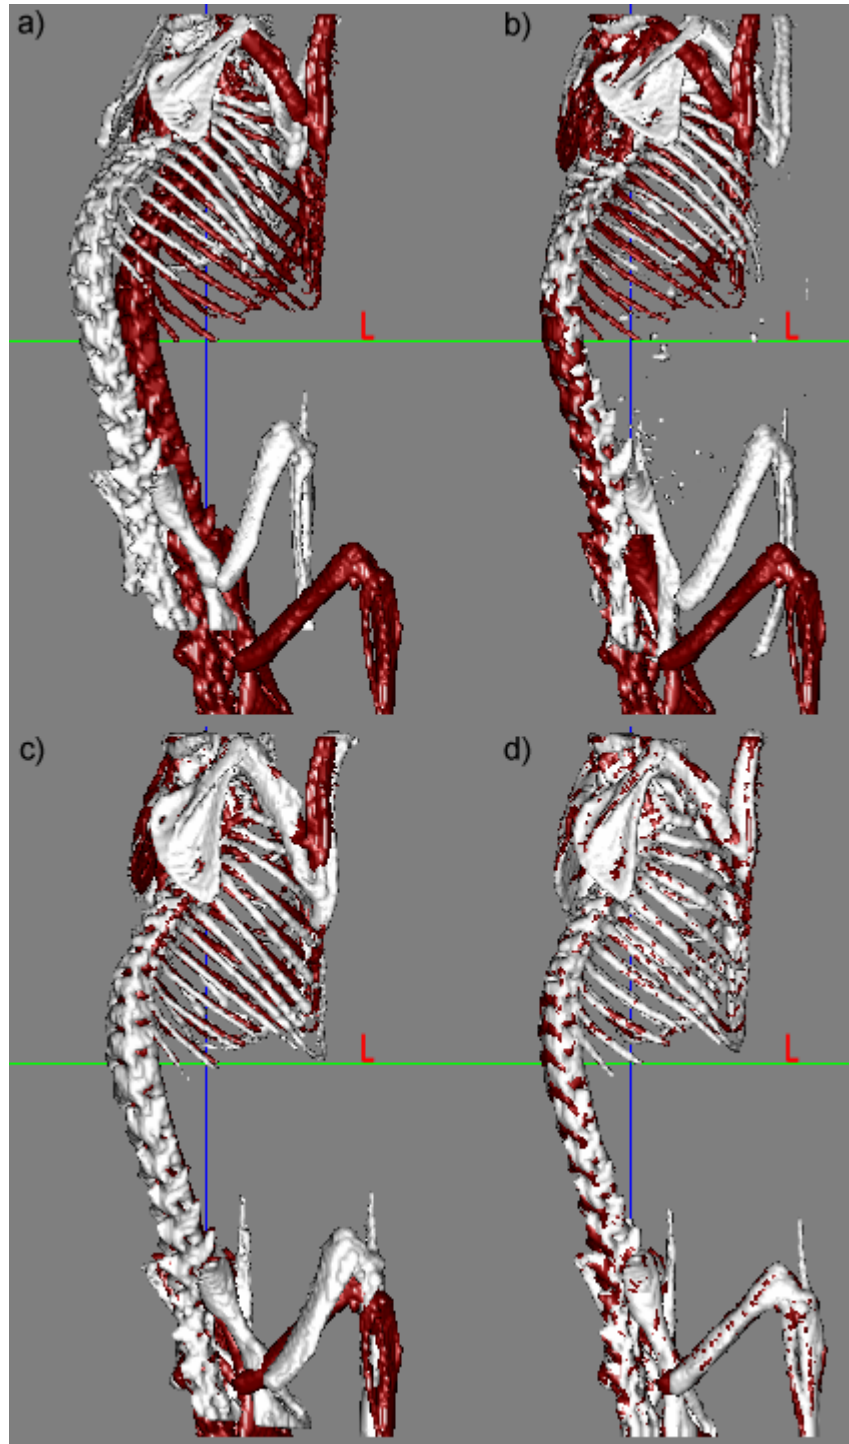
Bony structures in two micro CT volumes a) before registration, b) after ABA registration only, c) using only the robust point-based registration algorithm, and d) using both the point-based registration and the ABA algorithms.
